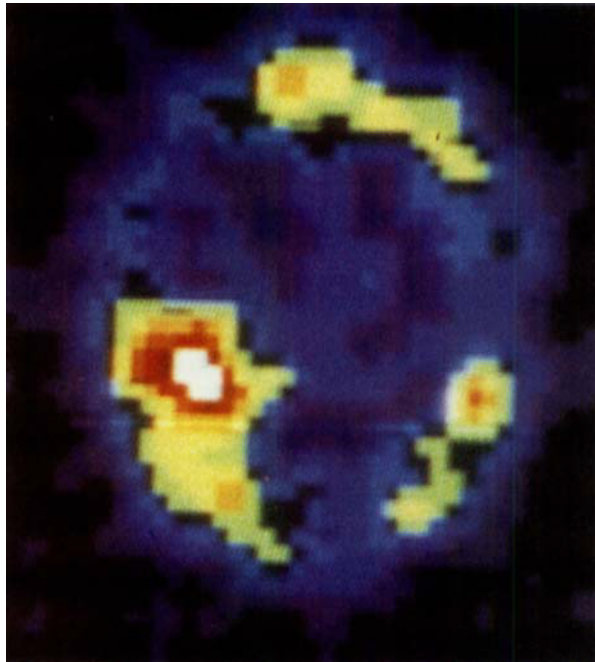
A SPECT study (BW 431/31) demonstrating multiple brain metastases.
